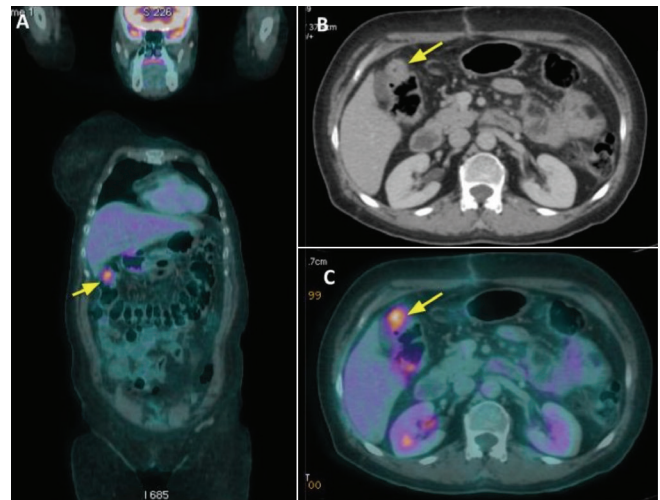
Focal region of increased metabolic activity (yellow arrow) demonstrating standardized uptake value of 8 involving hepatic flexure of colon on fused coronal (A) and fused axial (C) images of FDG PET-CT. Corresponding axial CT image (B) from PET-CT scan demonstrate focal thickening of colon wall (yellow arrow).
